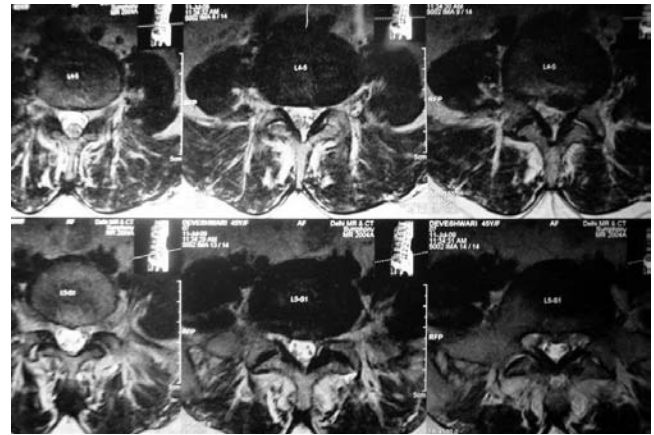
Left para central protrusion at L4-L5(small white arrow) compression at left L5 nerve root (long white arrow). Diffuse disc bulge at L5-S1(small white arrow) with no nerve root compression (long white arrow). MRI findings are well correlating with clinical findings.
